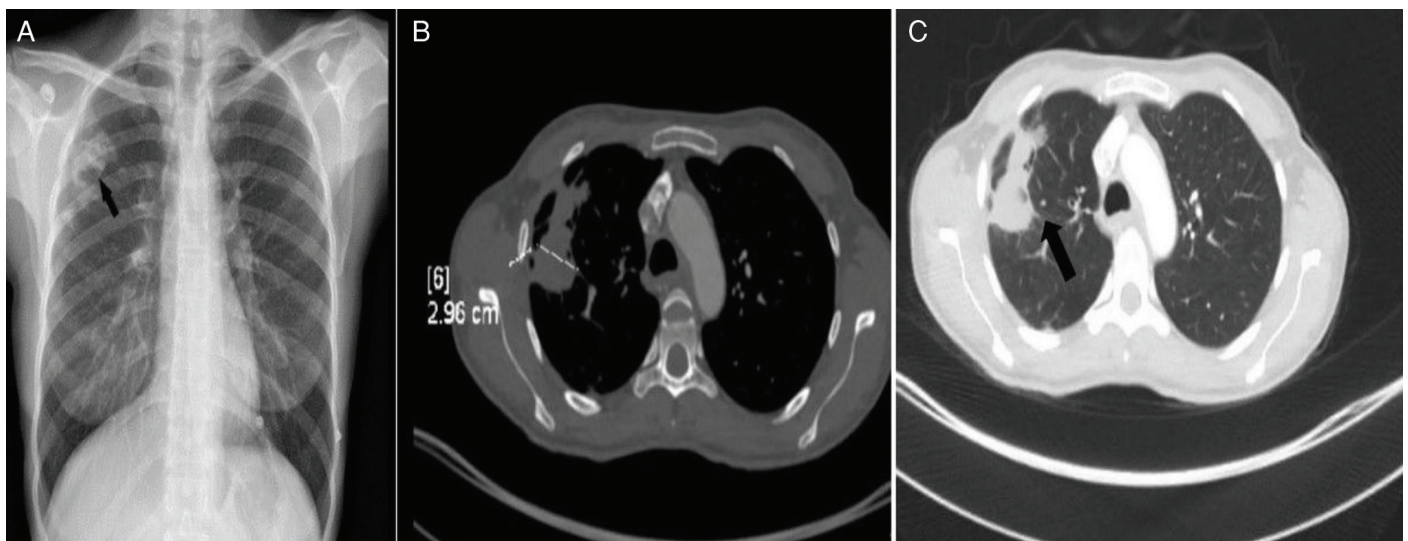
Chest radiograph and CT images. A) Chest radiograph showing consolidation in the right middle/upper lung zones (black arrows). B) Soft nodule with right lung upper lobe apex and cavitation within the size of 53x29x36 mm reaching the anterior and horizontal fissure. C) Interlobular septal thickness increases near the lesion ground-glass density increasing traction bronchiectasis and fibroatelectasis (black arrows)
